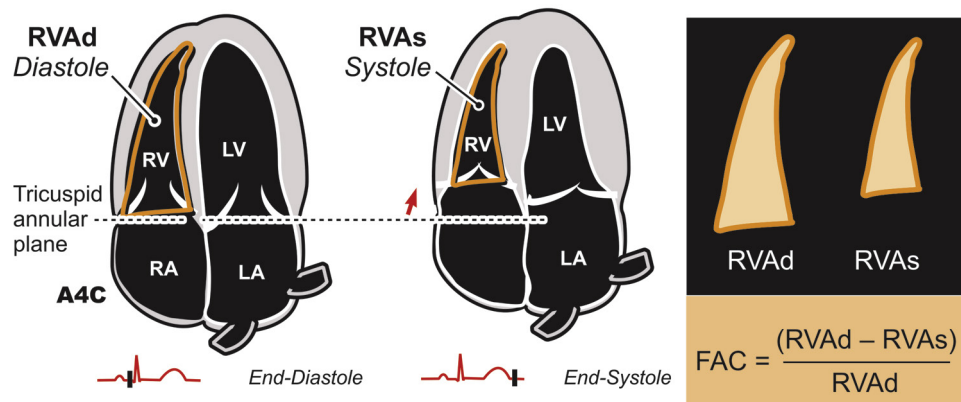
Right ventricular area (RVA) measurement and fractional area change (FAC) used to assess RV function with the apical four-chamber view (A4C). LA, Left atrium; LV, left ventricle; RA, right atrium; RV, right ventricle.
